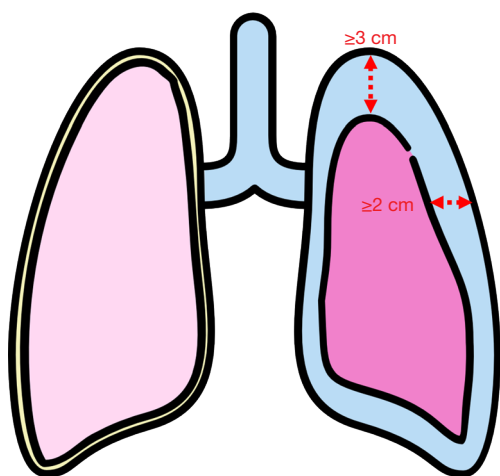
Pneumothorax is classified as large on a frontal chest X-ray if the distance from the margin of the lung to the chest wall is 2 cm from the chest wall at the level of hilum or 3 cm from the apex of the lung. On CT scan a large pneumothorax occupies >20% of the ipsilateral hemithorax.
